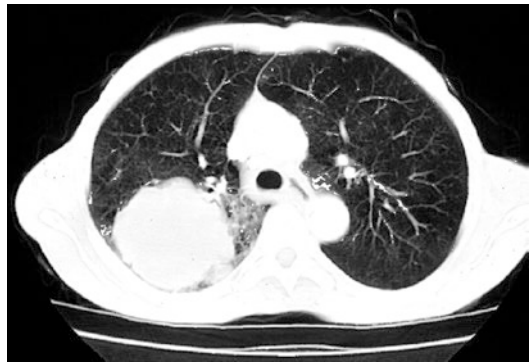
Small cell lung cancer in right upper lobe (chest CT scan)
